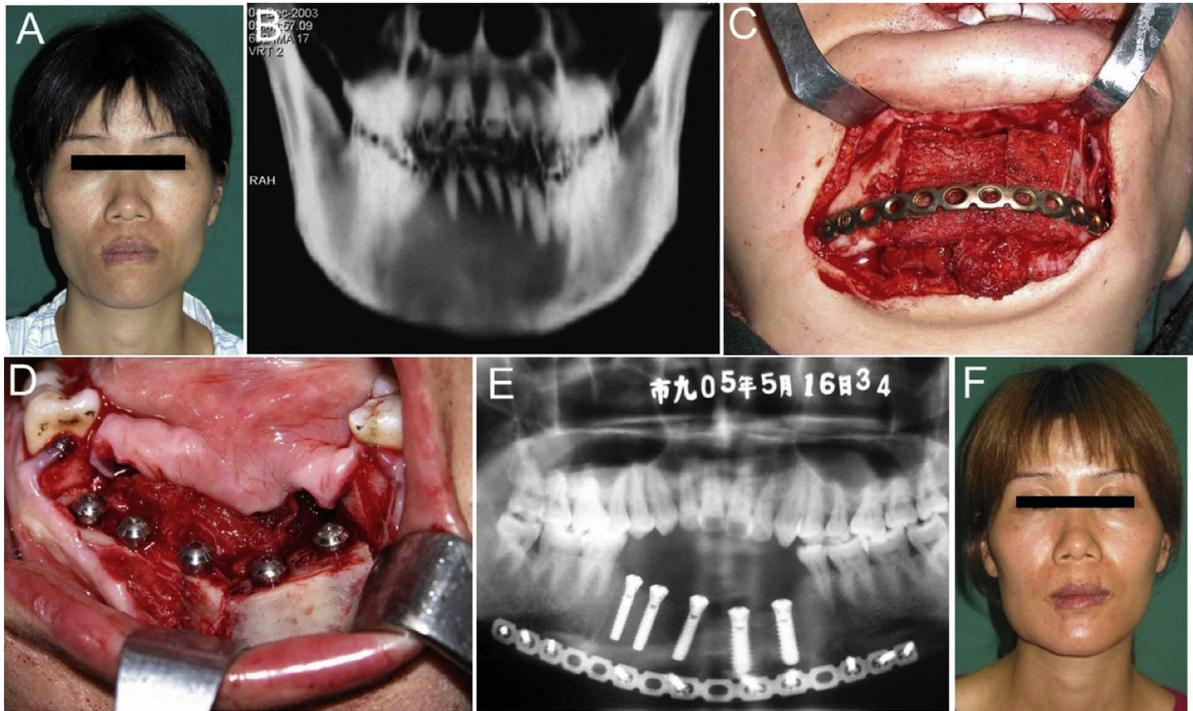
A 35-year-old female patient with osteofibroma. (A) Facial photograph before surgery; (B) osteofibroma of the mandible; (C) mandibular reconstruction with a DCIA flap; (D) simultaneous dental implant placement; (E) panoramic radiograph and (F) facial photograph showing an excellent postoperative appearance and osseointegration of the dental implants.
